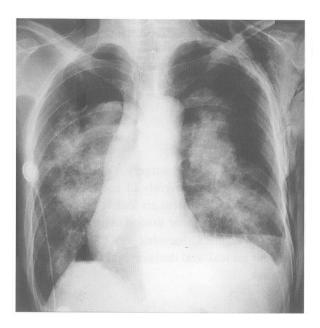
A chest X-ray on admission showing bilateral pneumothorax, multiple lung nodules, and pleural effusions.
